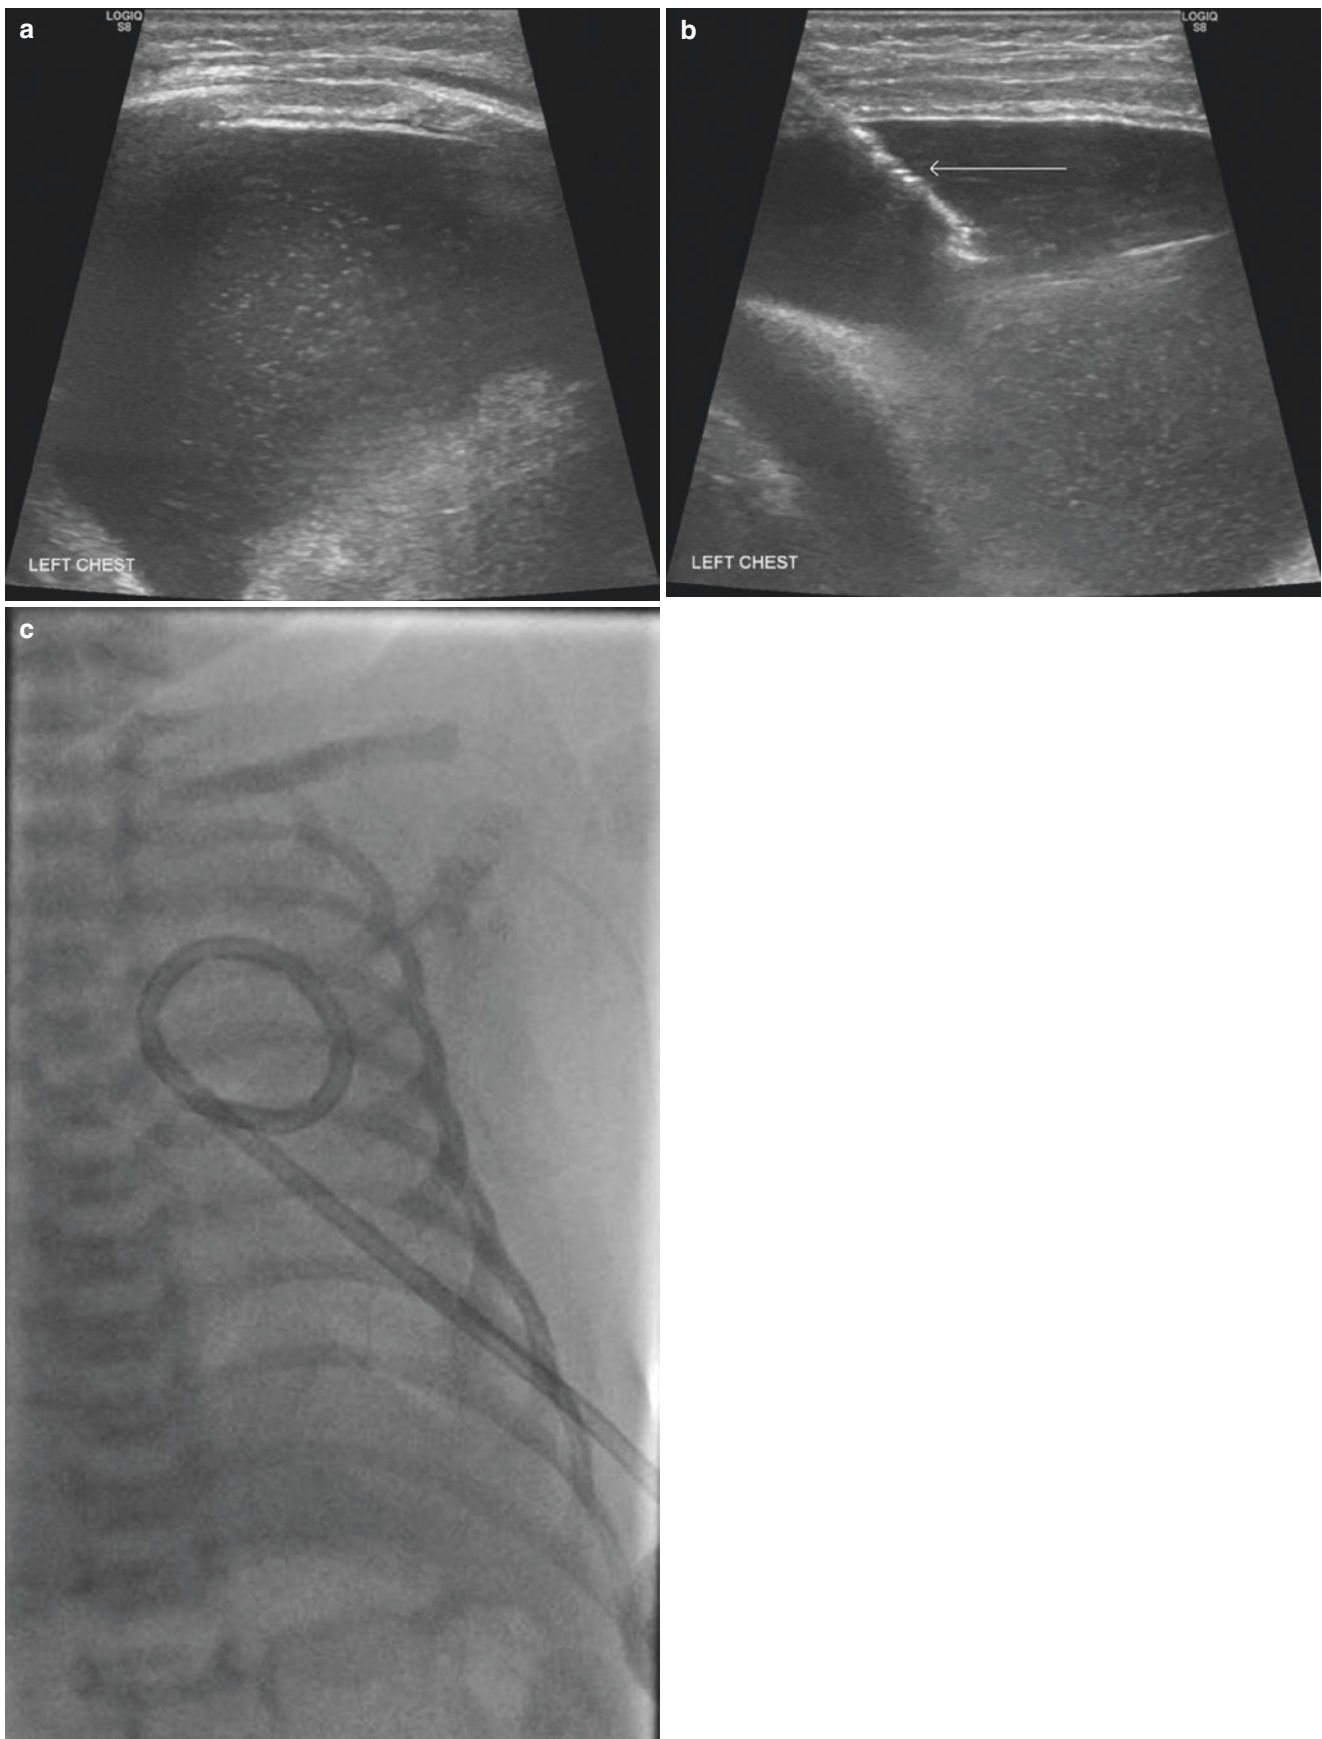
A 20-day-old patient with a left-sided congenital chylothorax. Initial ultrasound evaluation revealed a small to moderate effusion minimally complex effusion (a). Under ultrasound guidance, a 5 Fr
